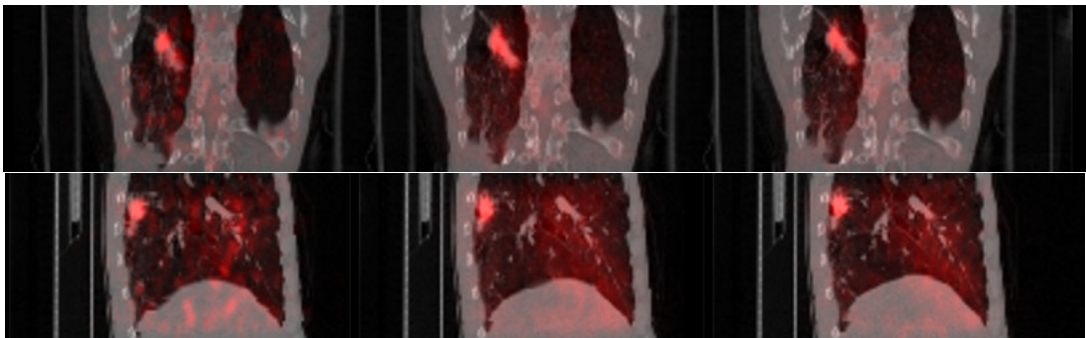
Patient 1. Coronal (top) and sagittal (bottom) fused PET and CT images, bins 3, 5, 8 (left to right).
